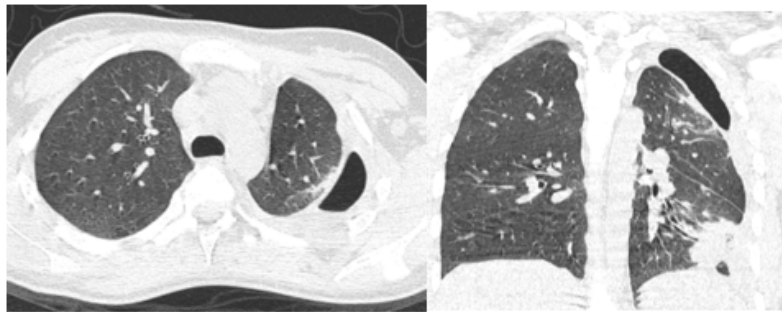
Axial CT scan in axial and coronal sections, after one month of drainage: persistence of a minim hydropneumothorax and the communication of an opposite bronchi.
